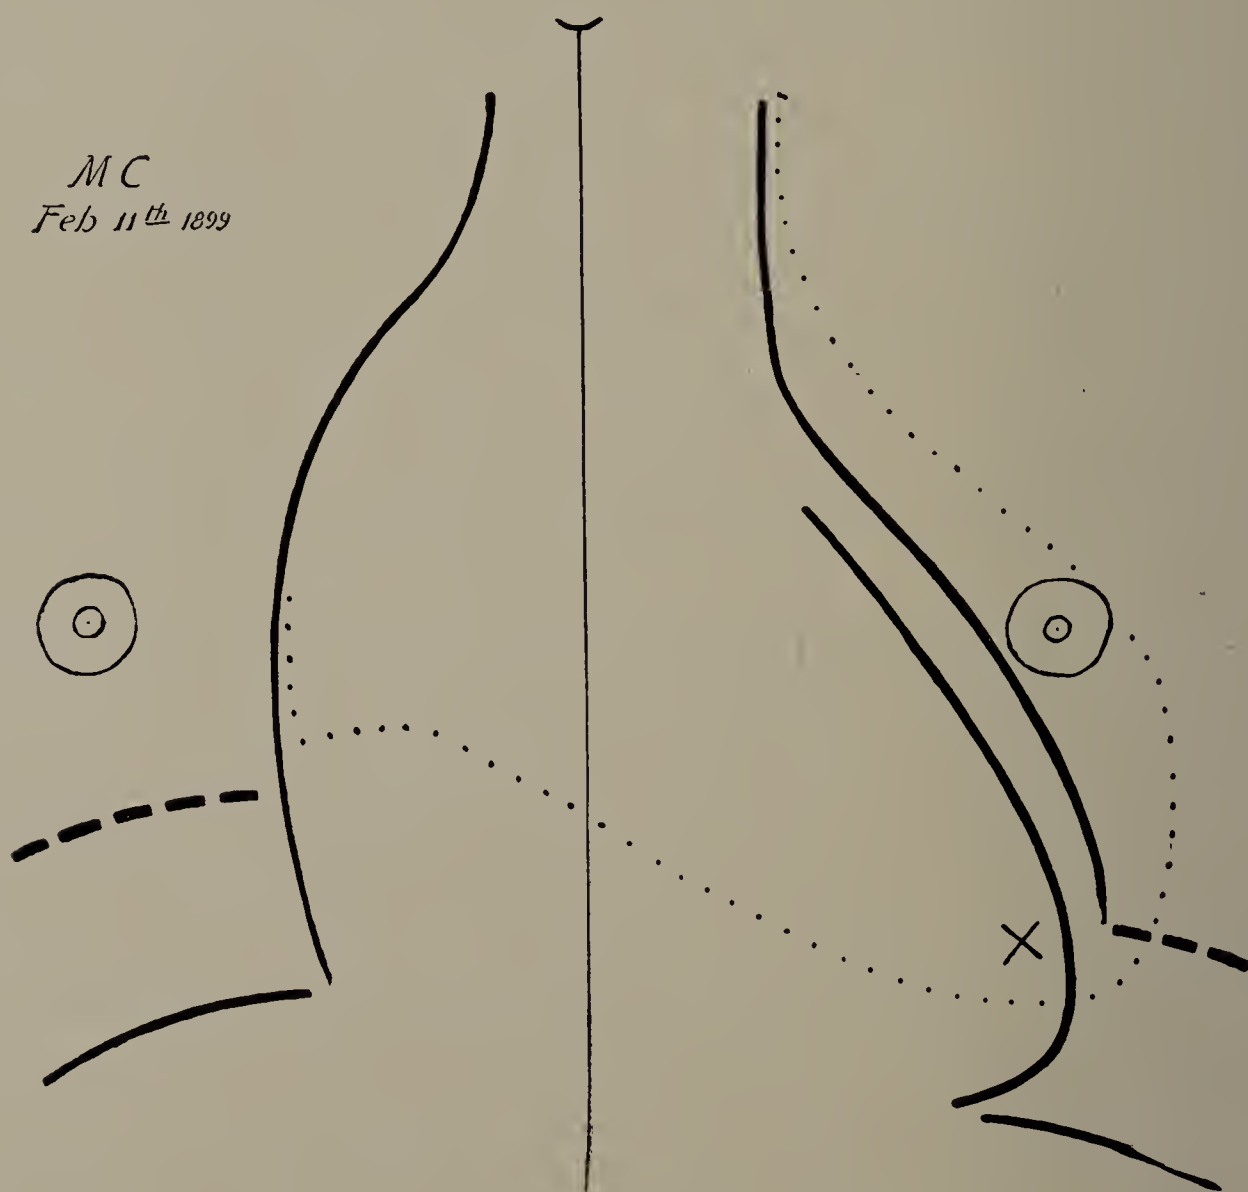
M. C. First X-ray tracing (one-third life size). Cardiac. The dotted line indicates the cardiac outline as determined by percussion; the full line (except of course the median line and the curve indicating the suprasternal notch) and the broken lines, the outlines of the heart and diaphragm as obtained by the X-rays. The outer full line on the left indicates the position of the heart in expiration; the inner, in full inspiration. The distance between the median line and the left border of the heart as obtained by the X-ray examination is slightly exaggerated, owing to the manner in which the outlines are recorded on the tracing cloth. The error is still greater by percussion.
